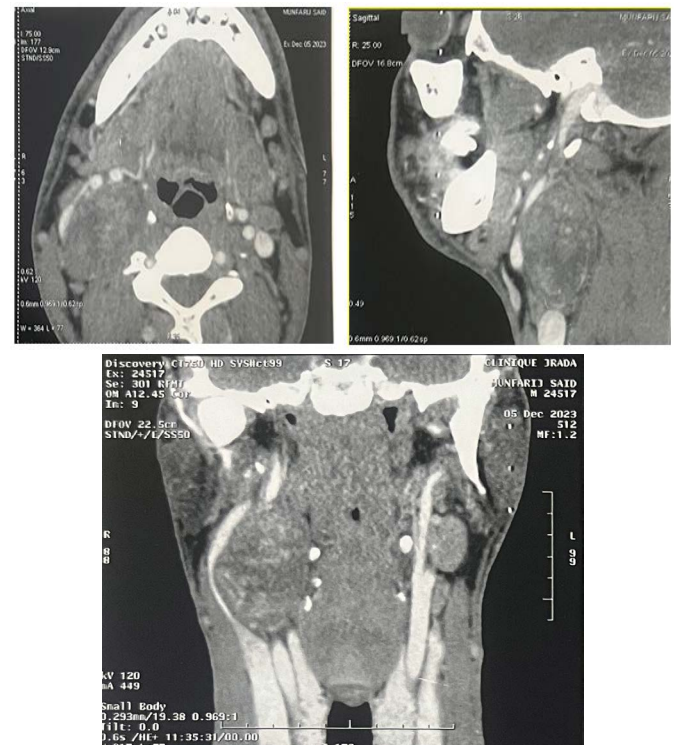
CT imaging of a vagal schwannoma (red arrow) on the right cervical side: (A) sagittal (B) axial and coronal (C) view.
